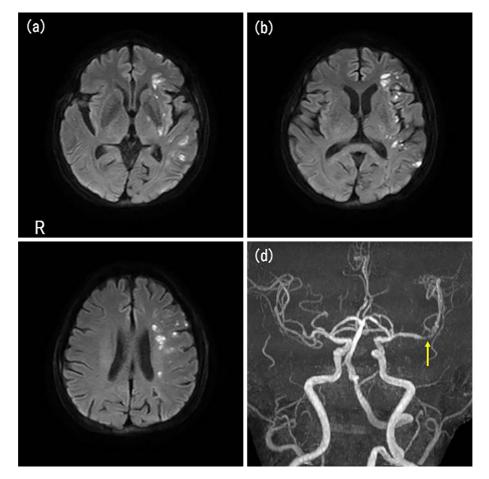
(a-c) Diffusion-weighted magnetic resonance imaging shows slightly enlarged infarctions in the territory of the left middle cerebral artery (the second stroke). (d) Magnetic resonance angiography shows residual stenosis of the left middle cerebral artery (arrow).
